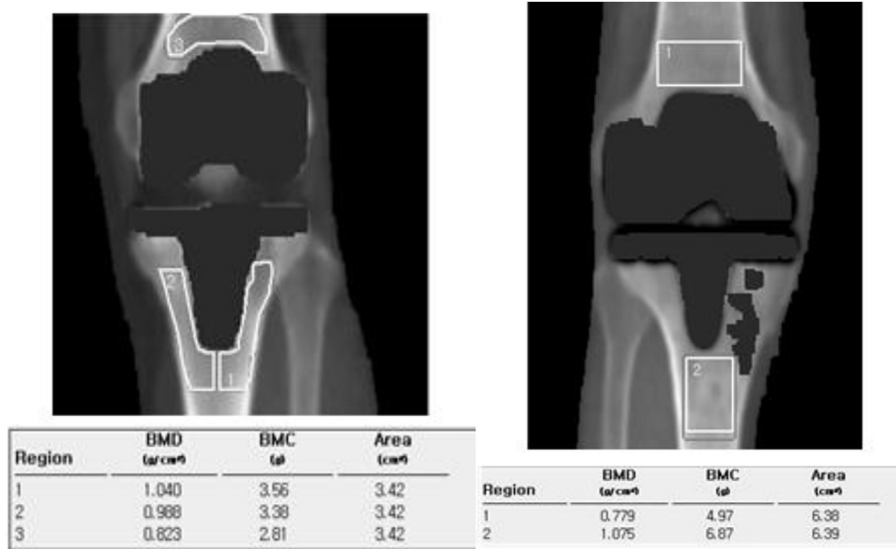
TKRA (total knee replacement arthroplasty) preoperation evaluation example using dual energy X-ray absorptiometry. BMD, bone mineral density; BMC, bone mineral content.
